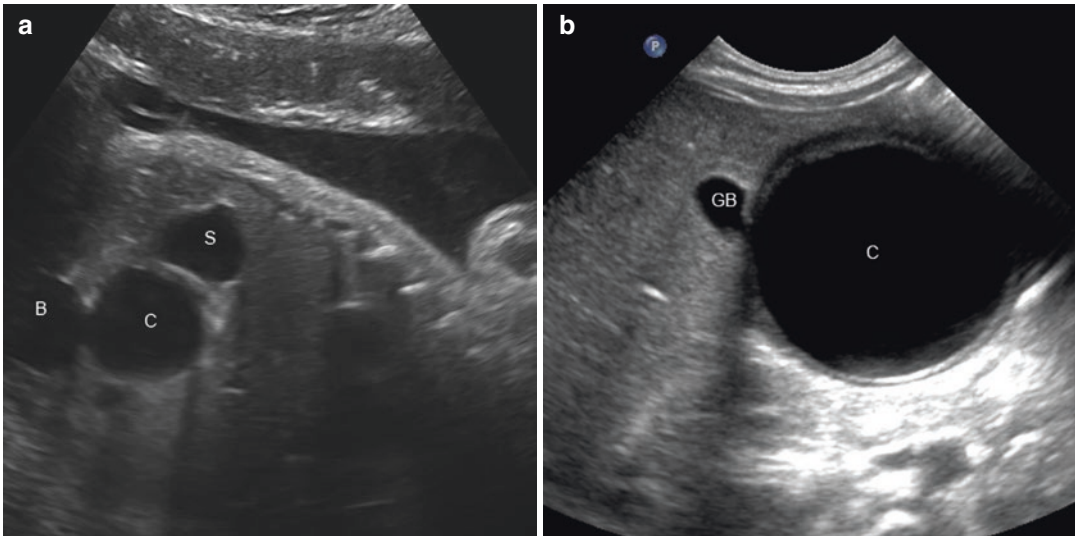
Gastric duplication cyst. (a) Prenatal ultrasound image demonstrates a thick-walled cyst (C) positioned between the stomach (S) and bladder (B). (b) Postnatal ultrasound demonstrates a thick-walled cyst in the expected location of the pylorus posterior to the gall
